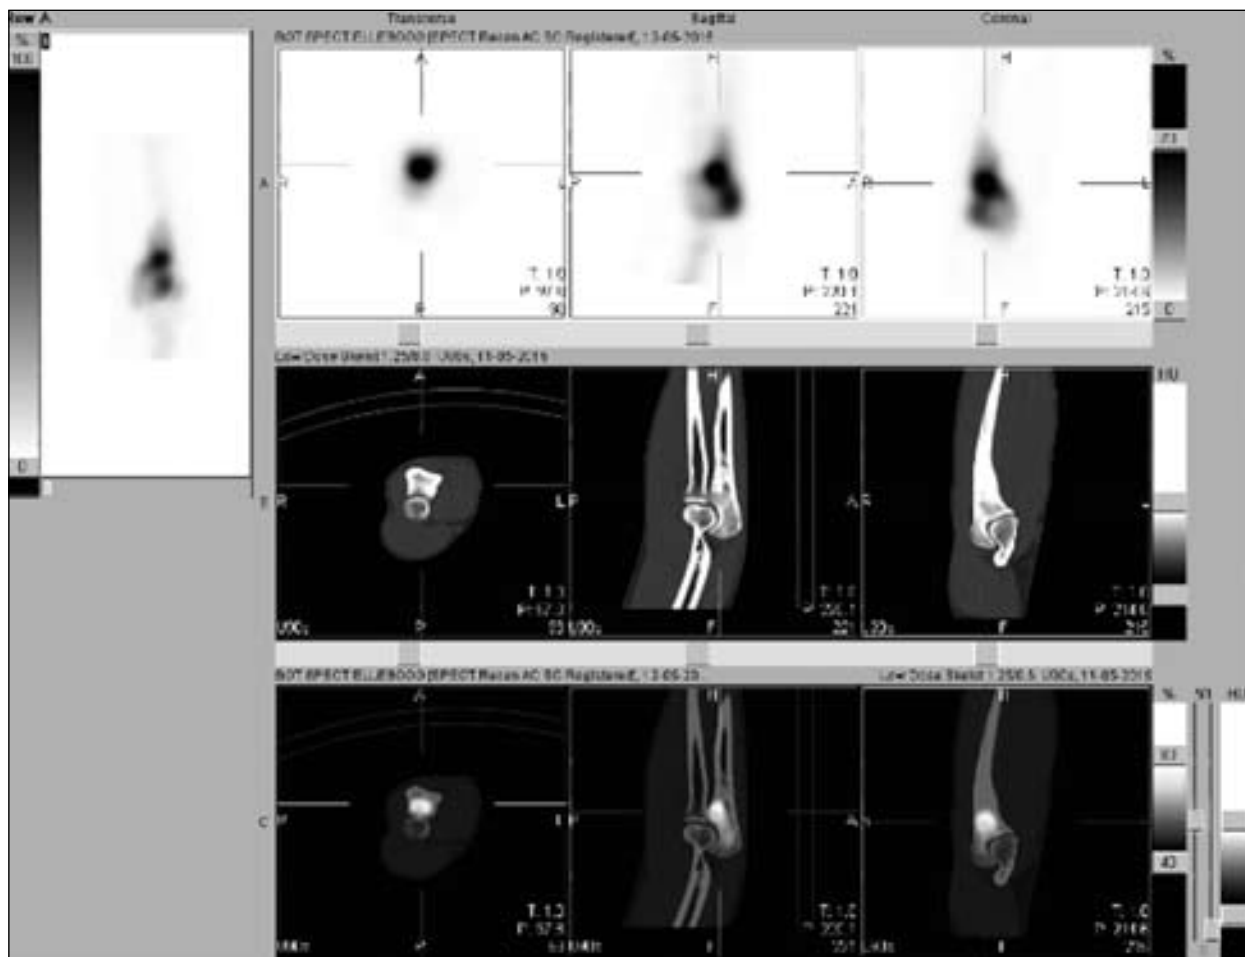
SPECT-scan: Hotspot about the proximal radio-ulnar joint.
